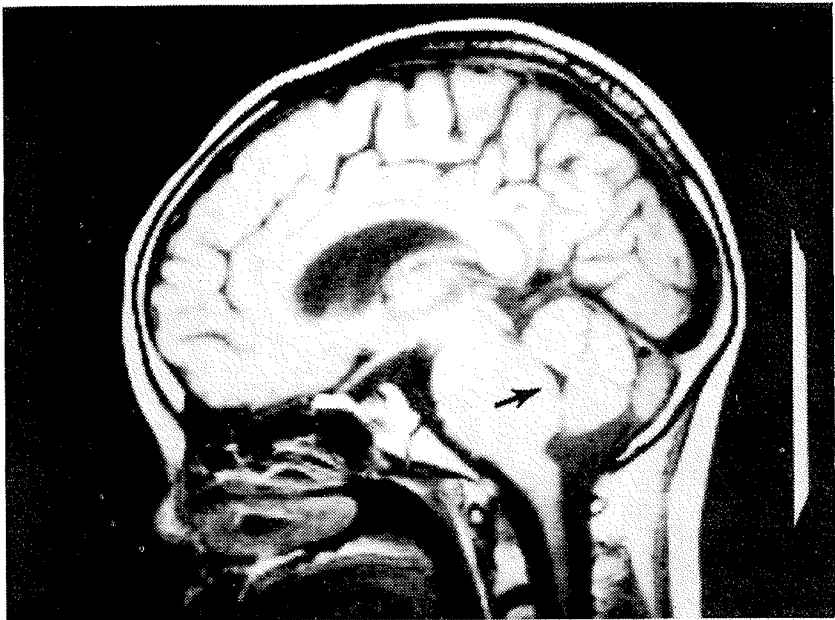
Pontine Glioma. Sagittal MR image shows expanded pons displaying the fourth ventricle (arrow).
